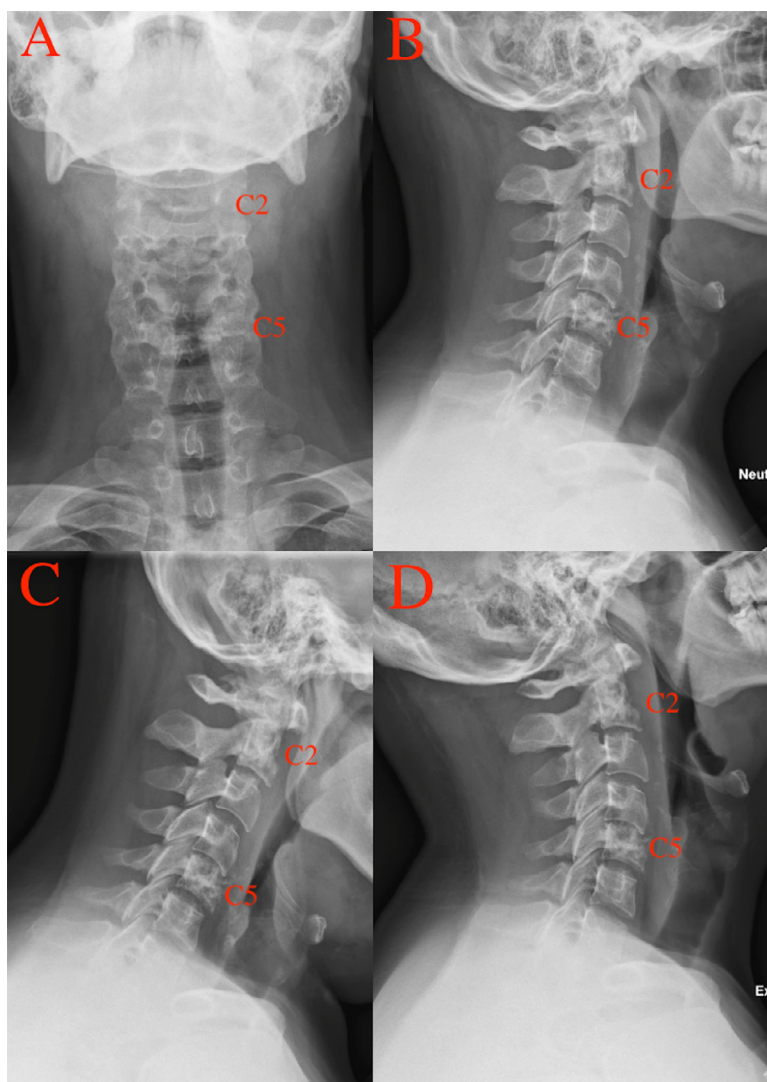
Cervical spine radiographs in the anterior-posterior (A) and sagittal views (B–D). Although partially obscured, the C2 body demonstrates lucent and sclerotic irregularities (C2 labeled in red). There is a mixed lucent and sclerotic appearance of the C5 body (C5 body labeled in red), with moderate-to-severe loss of height in the C4-5 intervertebral disc space (disc space labeled in red, denoted by arrow). Dynamic instability is not demonstrated with flexion (C)–extension (D).
